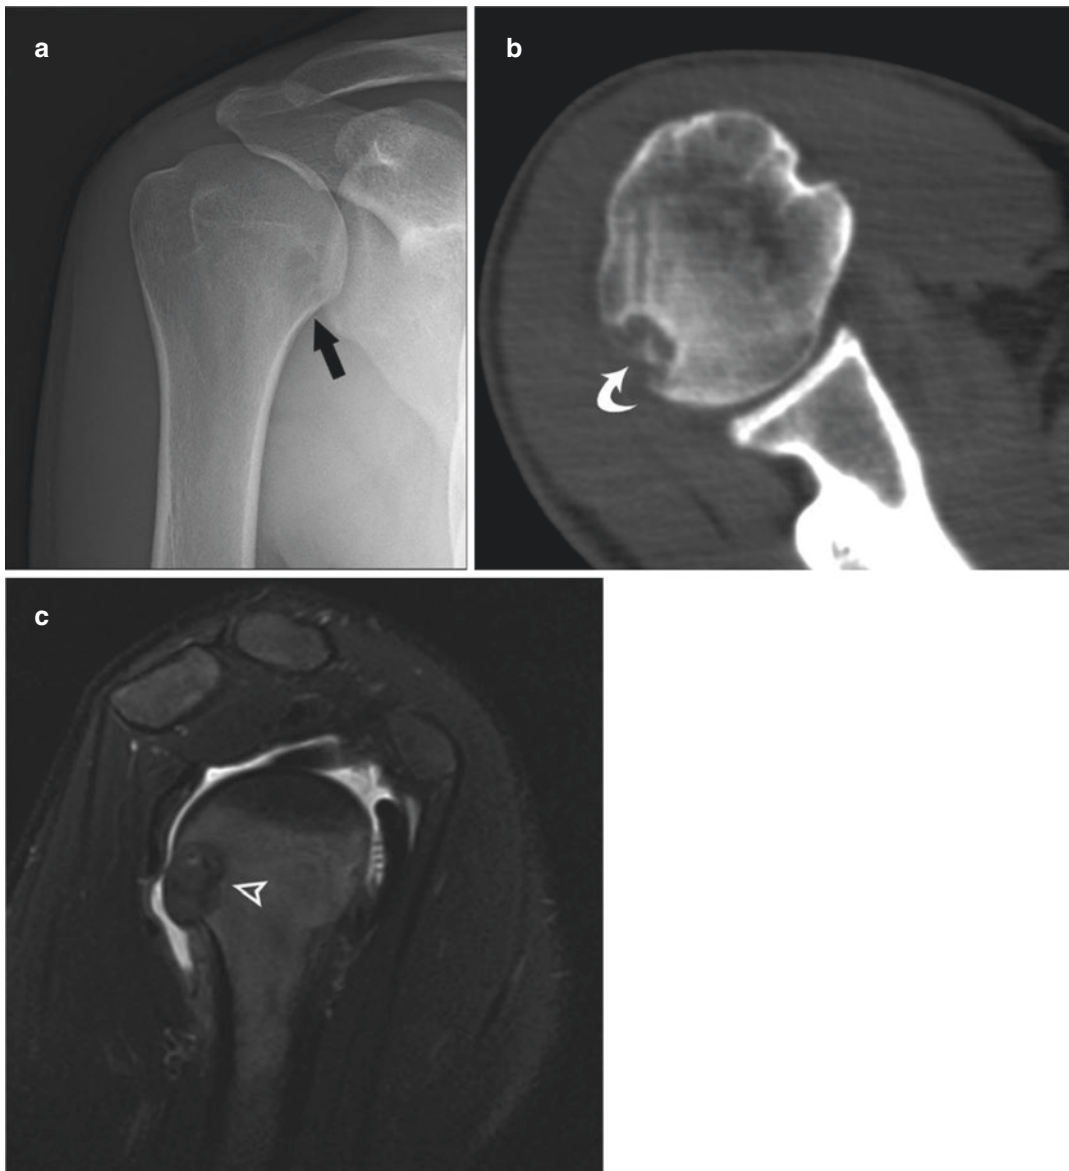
Chondroblastoma: 17-year-old male presents with right-shoulder pain. Radiograph (a) demonstrates a geographic 1B lesion (arrow) involving the medial proximal humeral metaphysis adjacent to the physal scar. Axial CT (b) reveals subtle calcifications (curved arrow) within the lesion. T2-weighted (TR4916, TE72) MR (c)
